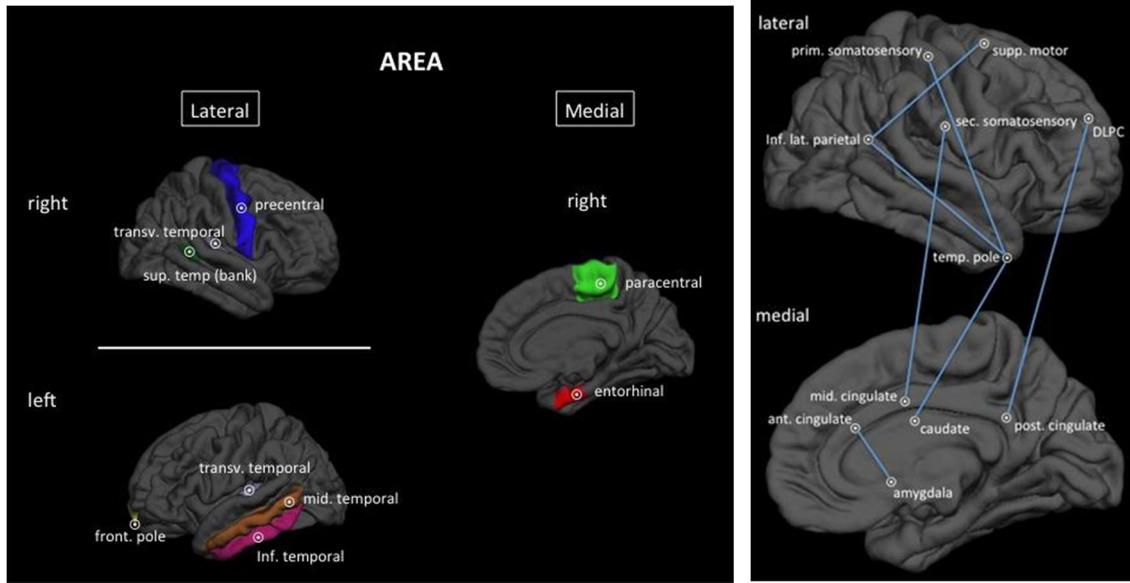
Regions that allow for accurate discrimination of the chronic migraine brain from that of an episodic migraineur. (20) Structural measures (i.e. cortical thickness, volume, surface area) of the colored brain regions allow for classification of the individual brain MRI as belonging to a person with chronic migraine vs. episodic migraine with 84.2% average accuracy. Similar model-building techniques can be used to construct classifiers that predict response to erenumab.
